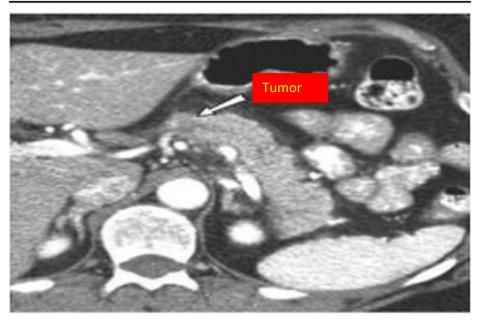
CT Scan image of pancreas cancer recognizing the tumor portion
